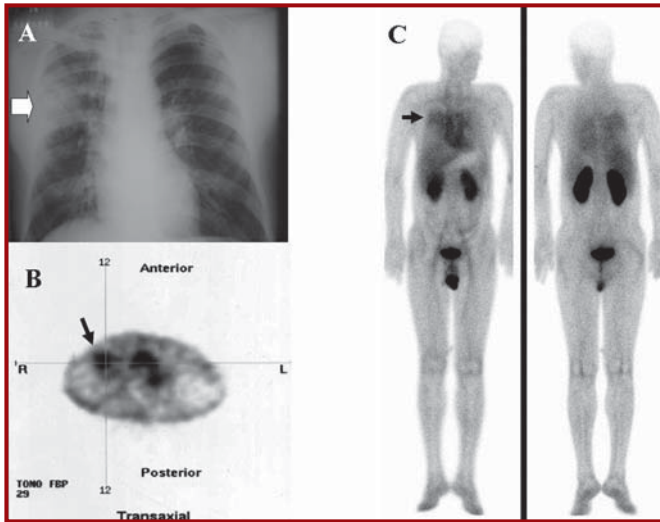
Chest X-ray graph (A) of a patient with adenocarcinoma reveals the tumor mass in the middle lobe of the right lung. Transaxial SPECT image (B) and anterior-posterior whole-body image (C) also demonstrate the increased Tc-99m GSH uptake in the tumor (arrows)
